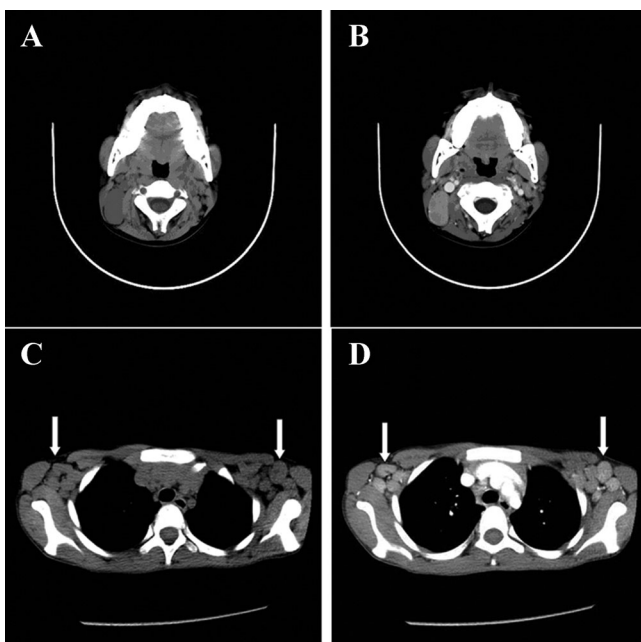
Unenhanced CT scans of HV type of CD in the right neck showed isolated demarcated round or lobulated mass lesions with equal density compared with adjacent normal muscle (A). Lesions were markedly and homogeneously enhanced in arterial phase, and their CT density was similar to the adjacent large vessels (B). CT scan of PC type of CD in bilateral axillae showed that the lesions compressed the surrounding structure with shifting of the latter but no vascular invasion was found (C), which was better seen on enhanced CT scan (D).
